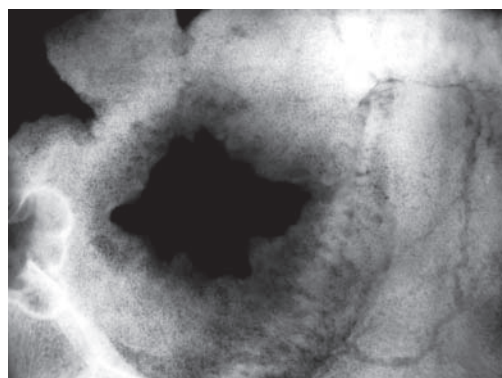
An X-ray which shows a thinning of the tables with a sclerosis of the surrounding area.
